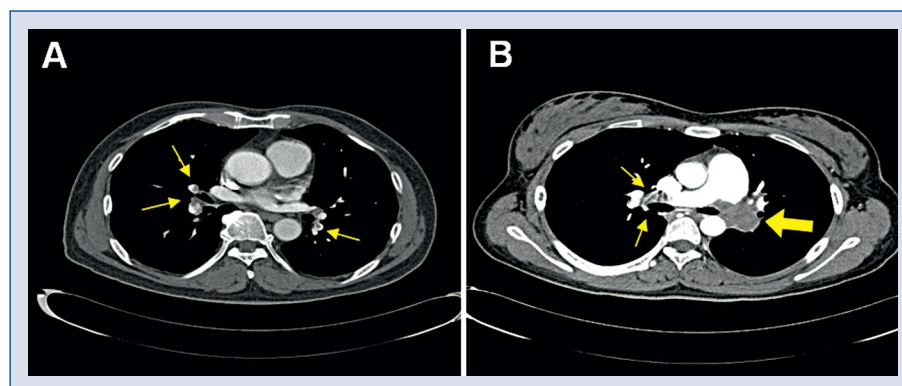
Chest computed tomography angiography shows multifocal small filling defects in both pulmonary arteries (arrows) (A) and large filling defects resulting in near total occlusion of the left pulmonary artery (wide arrow) and filling defect in right pulmonary artery (narrow arrow) (B).
